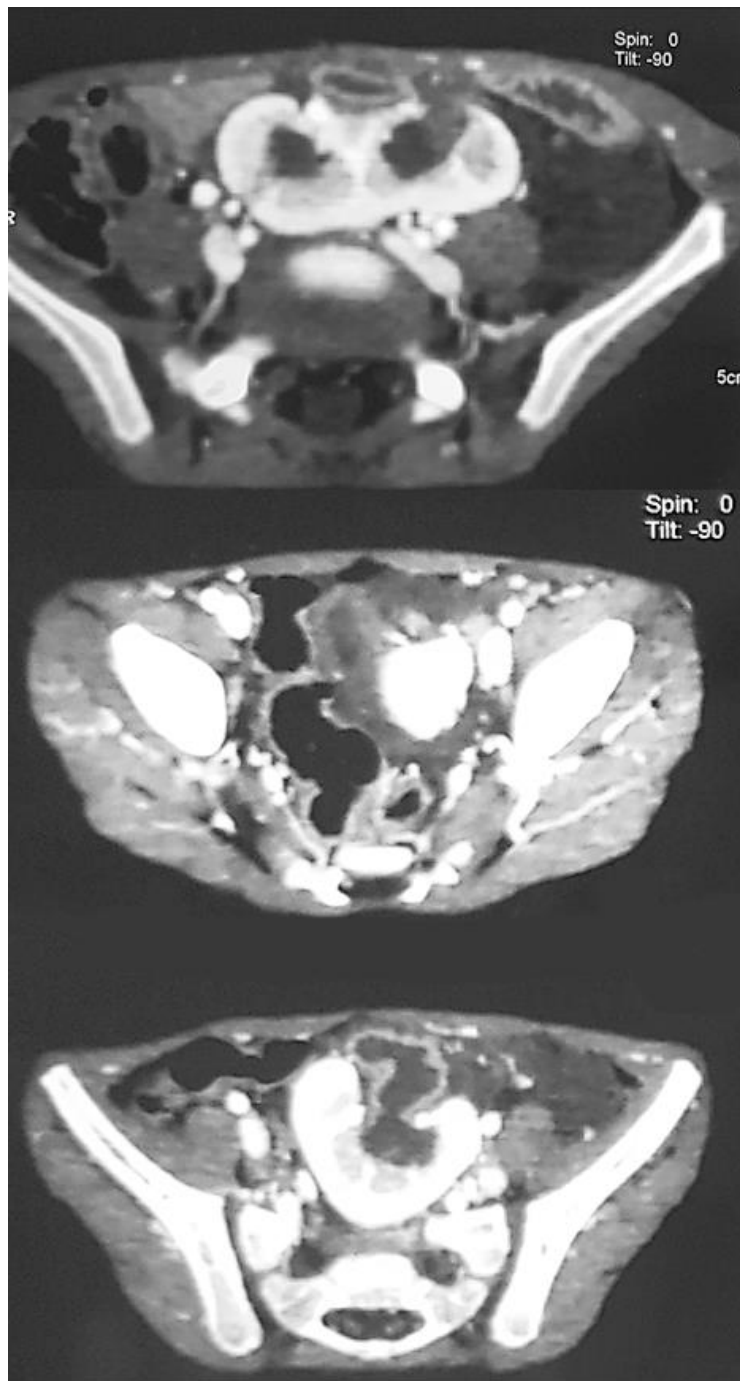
abdominal-pelvic CT scan showing an ectopic left kidney of pelvic location with an inferior polar fracture associated with a double pyloric system with a single ureter and a pyelo-caliceal dilatation with renal pelvis measured at 14 mm.
